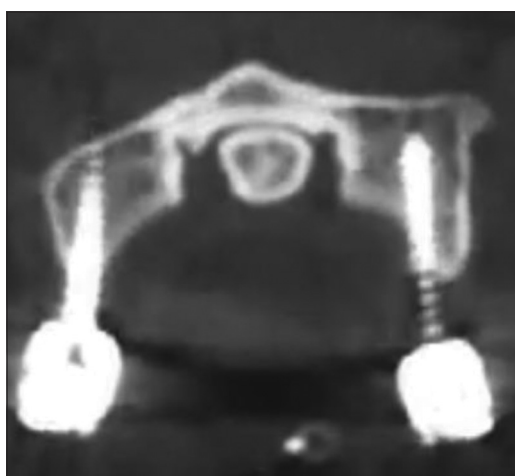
Postoperative CT C1 lateral mass fixation
